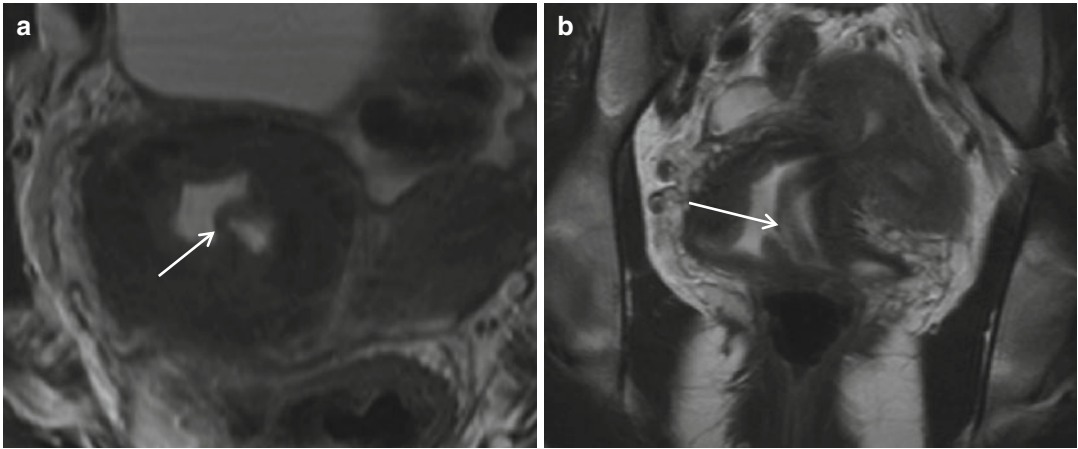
Complete septate uterus (Va). Fast spin-echo T2-weighted images on axial (TR 2820/TE110) (a) and coronal plane (b) (TR/TE 4070/94) show a normal-sized
